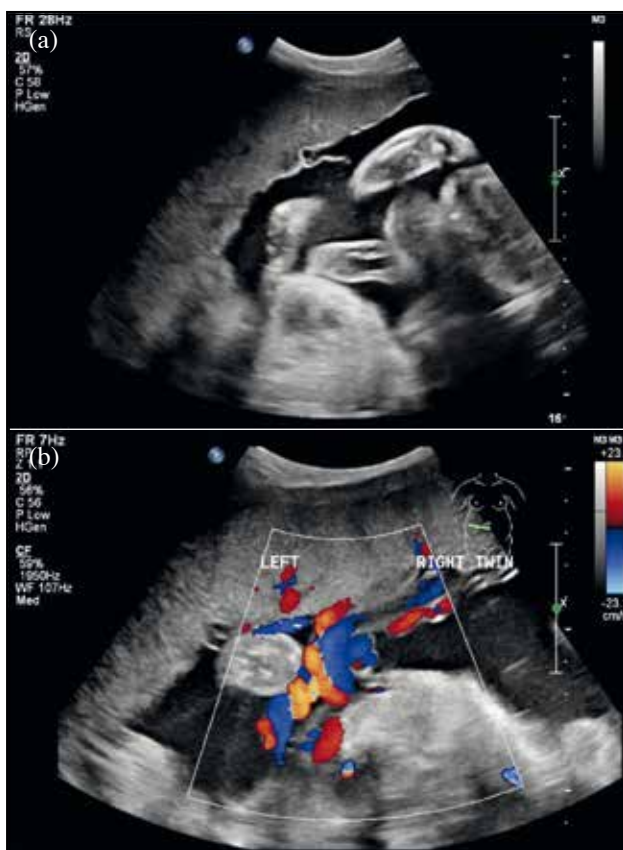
Case 3: ultrasonographs showing (a) remnant of the intertwin membrane and (b) 'cross-over' of the two cords
